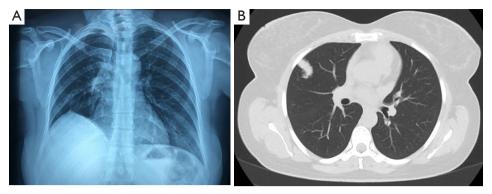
Radiological findings: tumor in upper right lobe. (A) Chest X-ray; (B) chest CT. CT, computed tomography.
